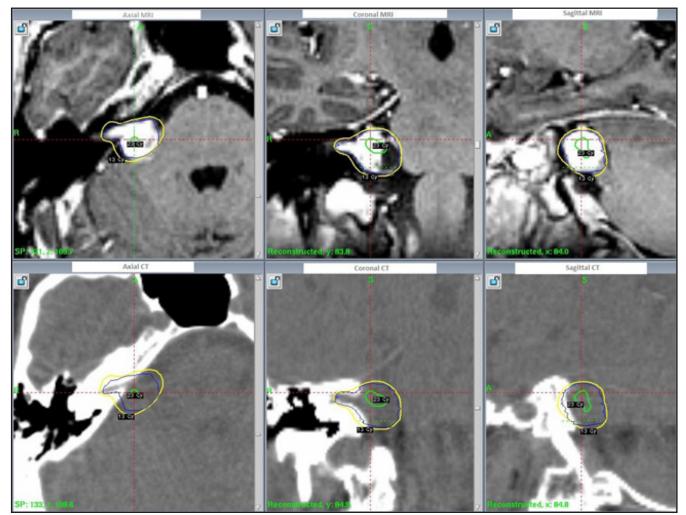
The figure shows Gamma Knife MRI/CT treatment planning contours.
